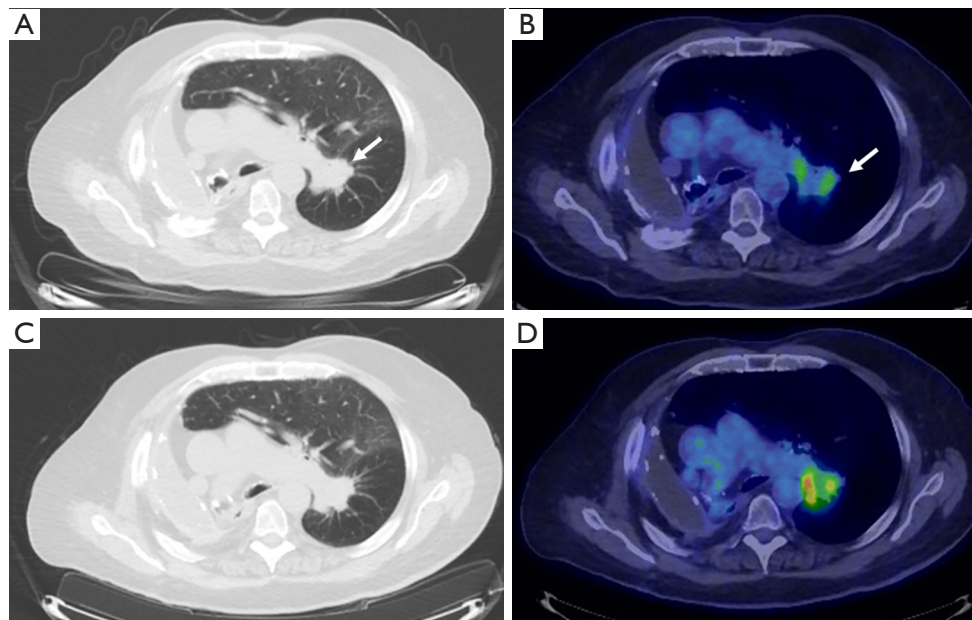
A 74-year-old man status post right pneumonectomy for squamous cell carcinoma was imaged for surveillance. Axial CT (A) and fused FDG PET/CT (B) images show mild uptake in the left hilum (arrows). Follow-up scan obtained 4 months later demonstrated unchanged size (C) but interval increase FDG uptake in the hilar mass (D), suspicious for recurrent disease.
